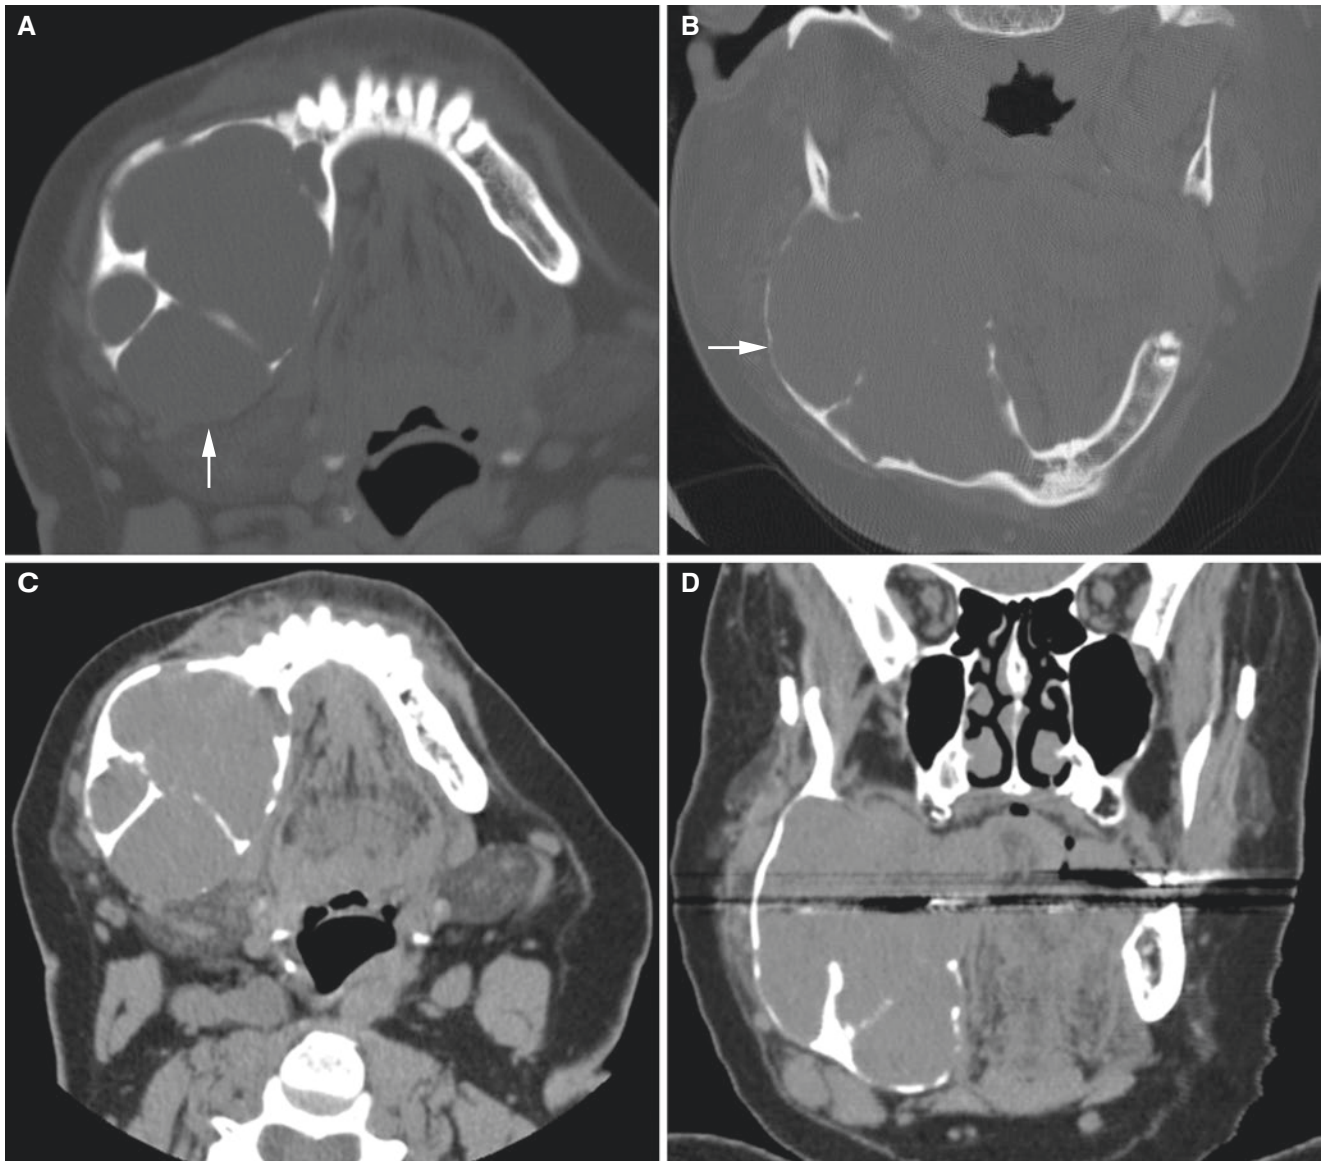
Ameloblastoma, solid/multicystic, mandible; 32-year-old female with pain-free swelling of the right mandible. (A) Axial and (B) coronal (bone window) CT images and (C) axial and (D) coronal
